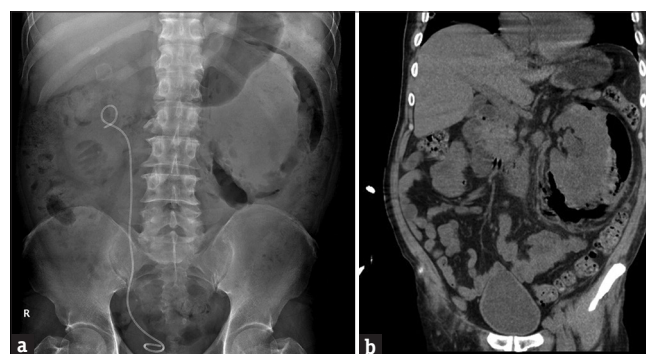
(a) KUB and (b) computed tomography scan of a 49-year-old male with left side severe emphysematous pyelonephritis (class 3B), large amount retroperitoneal gas accumulation and kidney destruction
